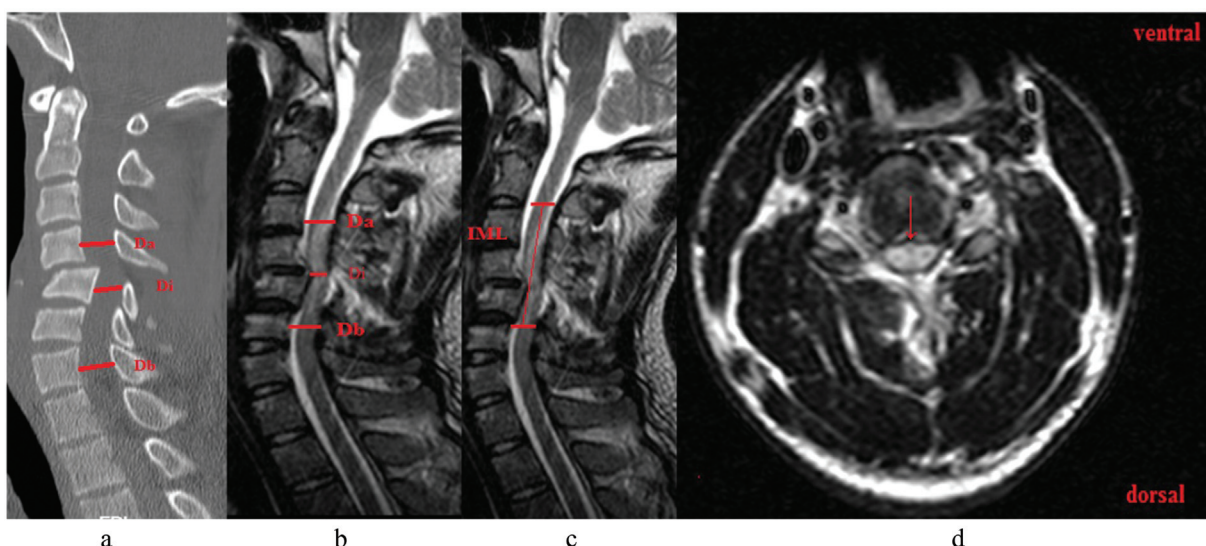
(a) midsagittal CT scan, (b) and (c) midsagittal T2-weighted, (d) axial T2-weighted obtained from 24 years old man with acute TCSCI at C4-C5 level (AIS grade C). (Da) anteroposterior spinal cord diameter at 1 vertebral level above; (Db) anteroposterior spinal cord diameter at 1 vertebral level below; (Di) anteroposterior spinal cord diameter at injury site; IML: rostrocaudal length of intramedullary hyperintensity at the injury site. Arrow in axial T2-weighted displayed intramedullary hyperintensity and cord compression in the affected zone.
